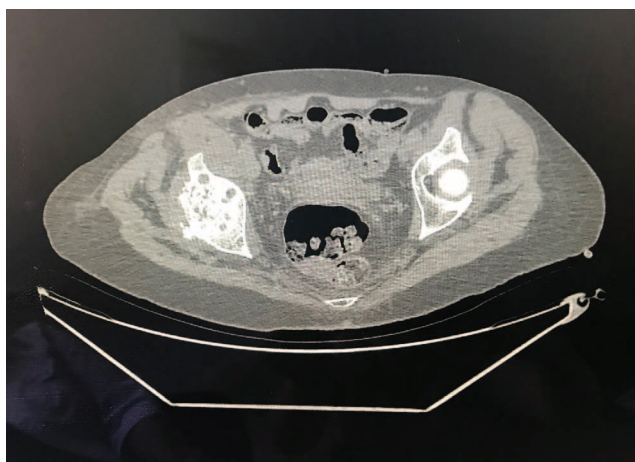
Computed tomography of the hip joints: the articular space of the right hip joint is sharply narrowed, the head of the femur is flattened, with the presence of areas of cystic restructuring and deep usurs, with marginal osteophytes, the roof of the acetabulum is expanded due to osteophytes, with many areas of cystic restructuring and deep usurs, ankylosis formation
